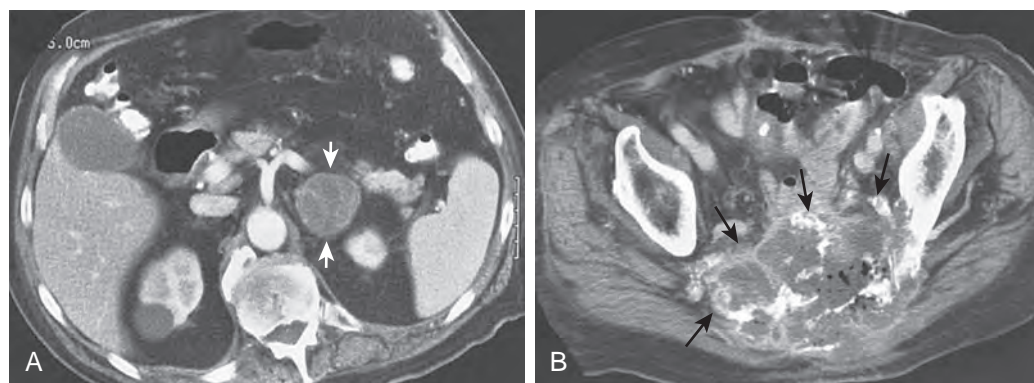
CT scan of recurrent rectal carcinoma with adrenal metastasis (T4bN1M1). A. Low-density mass (arrows) is seen in left adrenal gland. A cyst also is present in the right kidney. B. Large, irregular mass present in presacral space (arrows) with destruction of sacrum. Air bubbles within the mass indicate necrosis in the absence of clinical evidence of infection.
